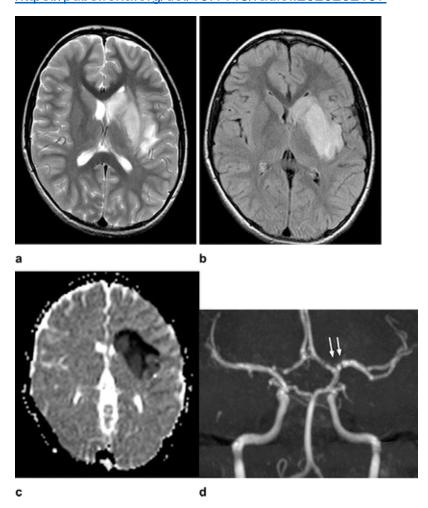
An MRI scan of a 12-year-old COVID-19 patient's brain. Images are of a previously healthy 12-year-old who presented with an ischemic stroke, seizure, difficulty speaking, and focal cerebral arteriopathy (FCA) as a result of COVID-19 infection. Images a, b, and c show the blood clot that lead to the stroke while image d shows the irregular shape and blood flow of the cerebral artery. Graphic: https://pubs.rsna.org/doi/10.1148/radiol.202020202197
